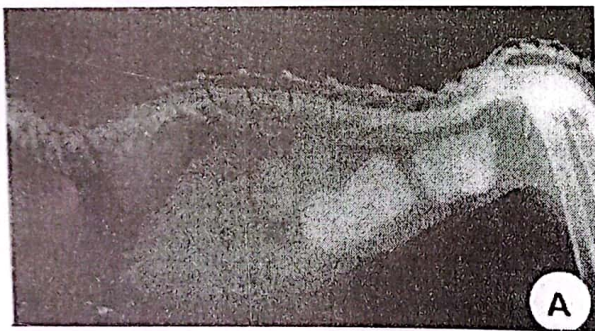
Lateral and ventrodorsal X-ray images of the previous case in Fig. (5) with obstipation and megacolon. Note the pathological bone disorders; kyphosis and lordosis of the vertebral column and the narrow pelvis.
